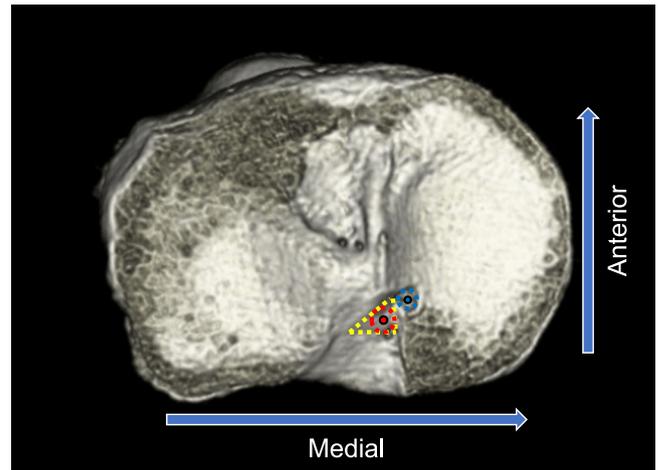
Measurement of the anatomical attachment and technical attachment positions. Three-dimensional CT-based tibial surfaces were used to confirm the positions of the anatomical and technical attachments of the MMPR. The anatomical attachment of the MMPR was the midpoint (red point) of a regular circle (red dotted line) in a triangle (yellow dotted line) consisting of the anterior margin of the PCL attachment, lateral margin of the medial tibial plateau and posterior margin of the medial tibial eminence. The technical attachment is the midpoint (blue point) of the created tibial tunnel (blue dotted line). The anterior and medial distances from the anatomical to technical attachments were measured. CT, computed tomography; MMPR, medial meniscus posterior root; PCL, posterior cruciate ligament.
